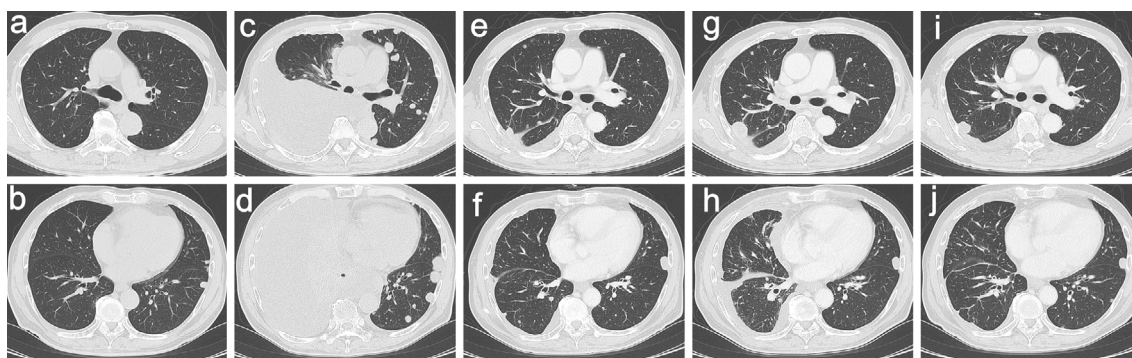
Computed tomography of lung metastases from lenvatinib failure to sorafenib and regorafenib. (a, b) Multiple small lung metastases before lenvatinib treatment. (c, d) Numerous lung metastases and massive right pleural effusion were observed three months after starting lenvatinib. (e, f) The lung metastases had shrunk, and the pleural effusion had nearly disappeared three months after starting sorafenib. (g, h) Five months after starting sorafenib, the pleural effusion had returned, and the lung metastases had grown. (i, j) The lung metastases shrank again four months after starting regorafenib.
